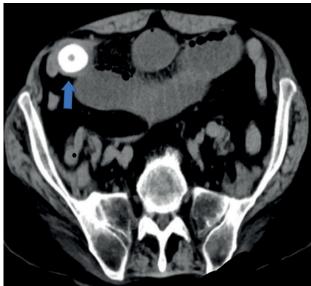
Axial CT abdomen showed presence of calcified lesion at ileum (blue arrow).
